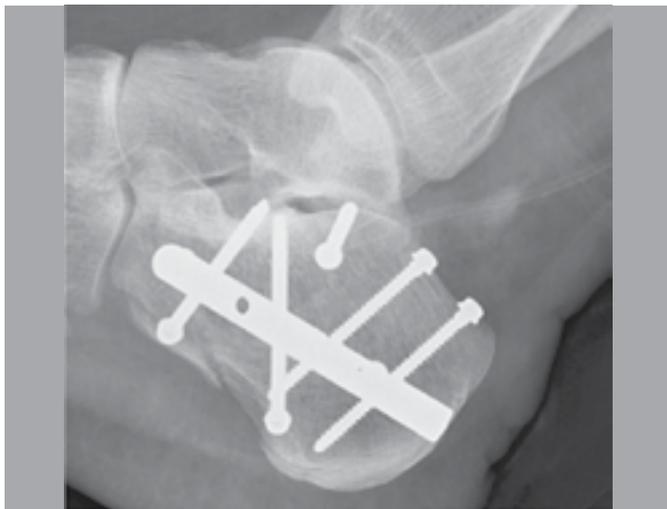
Lateral X-ray postoperatively C – nail.
